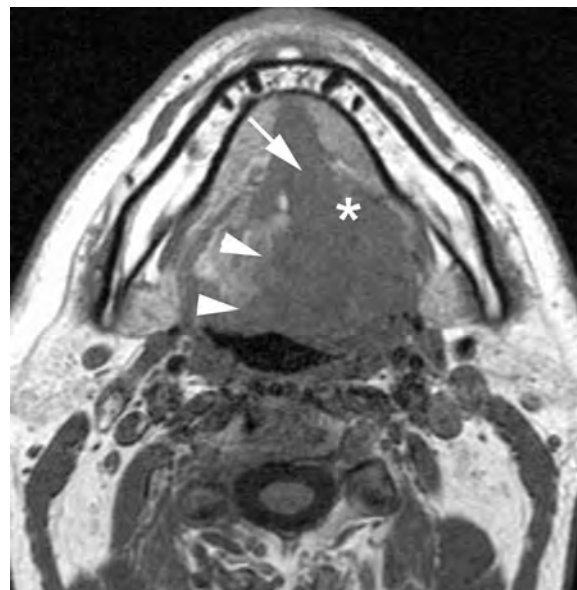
Patient with a left-sided tongue base cancer. Axial plain T1-weighted spin echo image show soft tissue mass growing over the midline (*arrowheads*), involving the left sublingual space (*asterisk*) and genioglossus/geniohyoid muscle (*arrow*)
